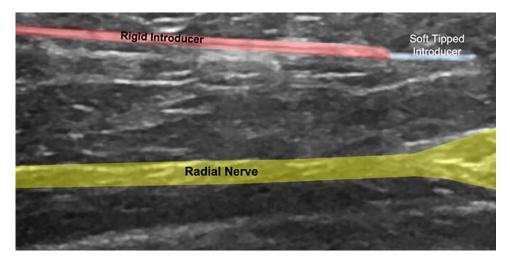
Axial ultrasound view of the radial nerve in the lower third of the upper arm.
